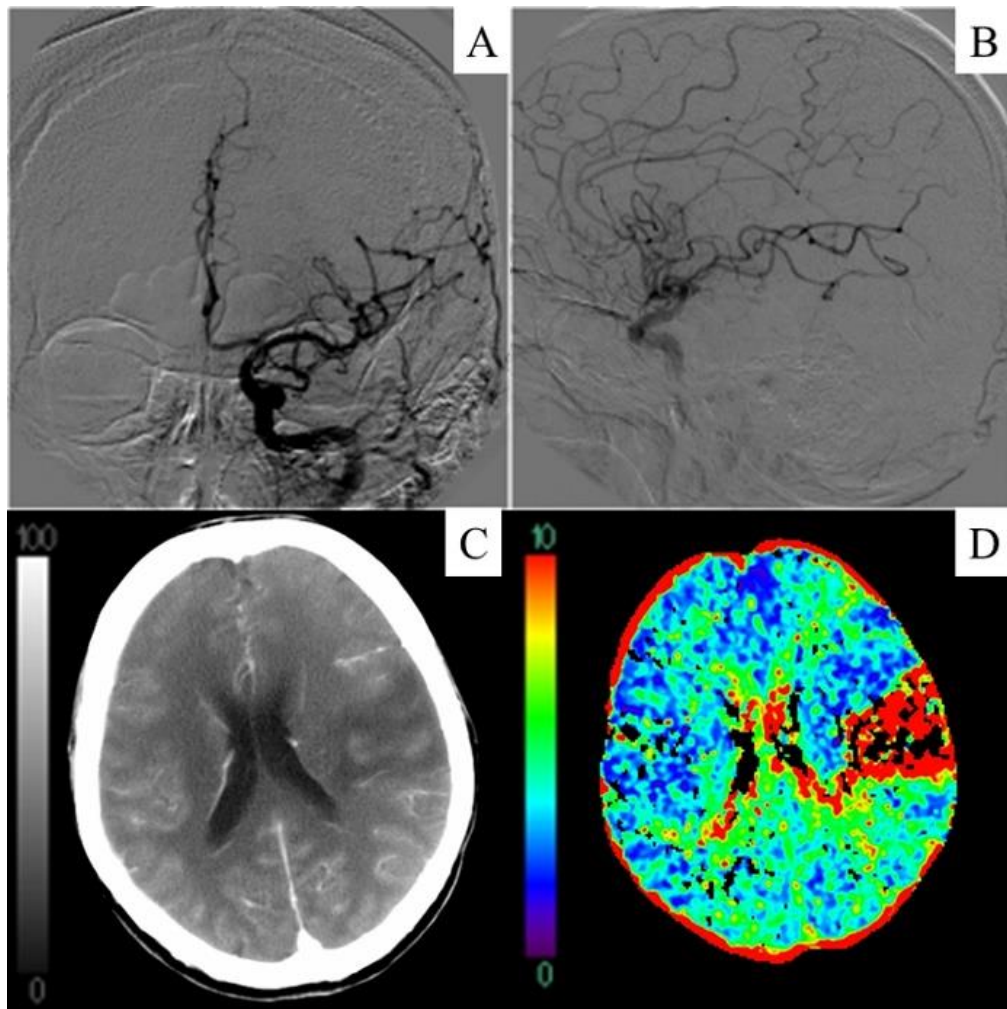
An example of the discrepancy between modified thrombolysis in cerebral ischemia (mTICI) 3 and reperfusion score (S_{CTP}) assessed on pre-treatment and 24h follow-up CT Perfusion (CTP). A-B) Frontal (A) and sagittal (B) views from the post-procedural digital subtraction angiography (DSA) which was scored mTICI 3. C-D) Average image (C) and time-to-maximum (T_{max}) map (D) from 24h follow-up CTP showing a large ischemic ($T_{max}>10s$) lesion in the left MCA territory, S_{CTP} for this patient was 18.5%.
